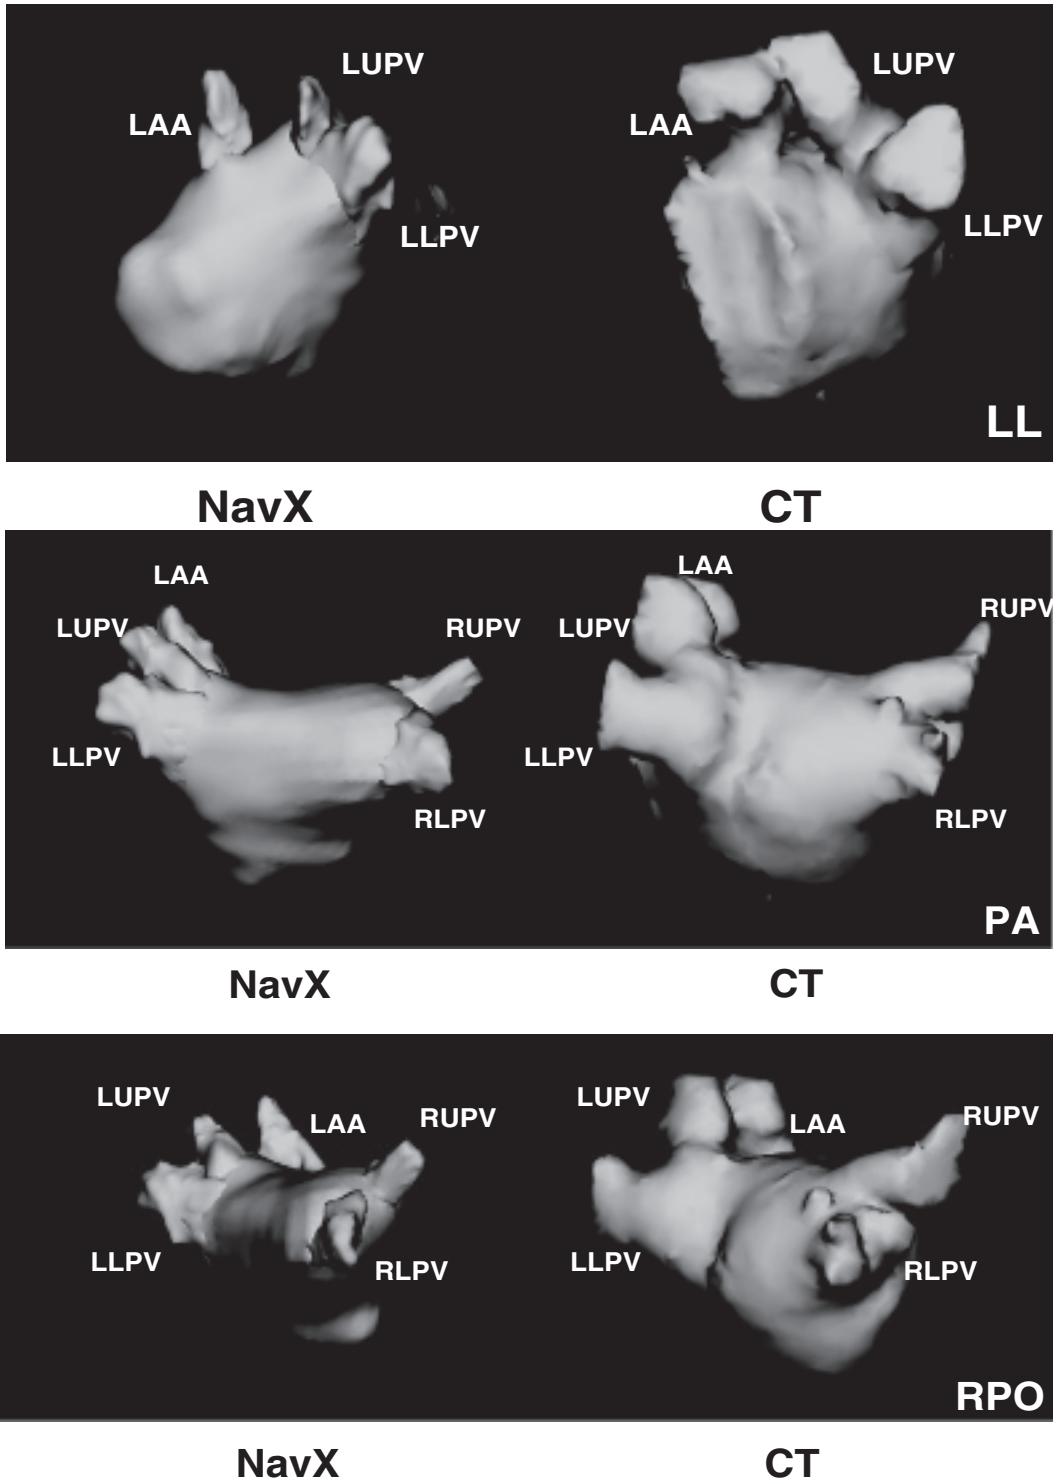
Left atrial 3D anatomy reconstructed on NavX using a multipolar (Lasso) catheter for automatic point acquisition, compared to the CT scan of the same patient from a LL, PA, and RPO view.
